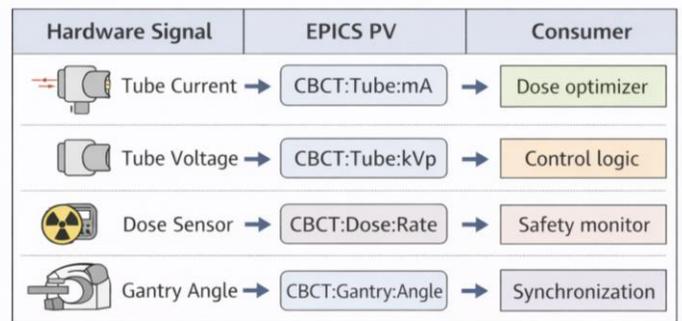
Example Mapping Between CBCT Hardware Signals and EPICS Process Variables Used For Monitoring and Control
